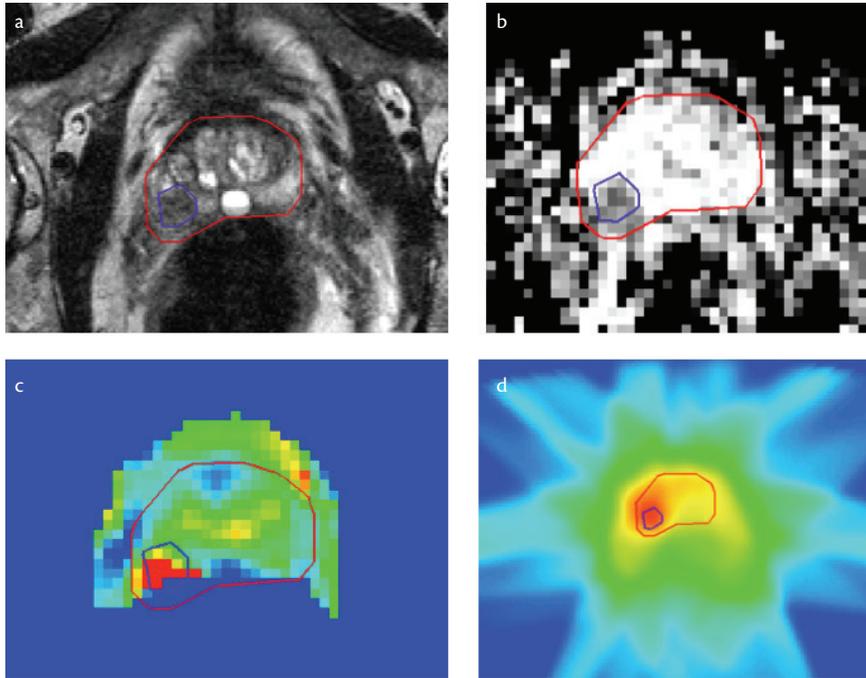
Example of the delineation of the macroscopic tumor area (GTV) on T2 weighted MRI (a), an apparent diffusion coefficient map derived from diffusion-weighted MRI (b) and a K^{trans} parameter map obtained from dynamic contrast-enhanced MRI (c) and the dose distribution (d).
